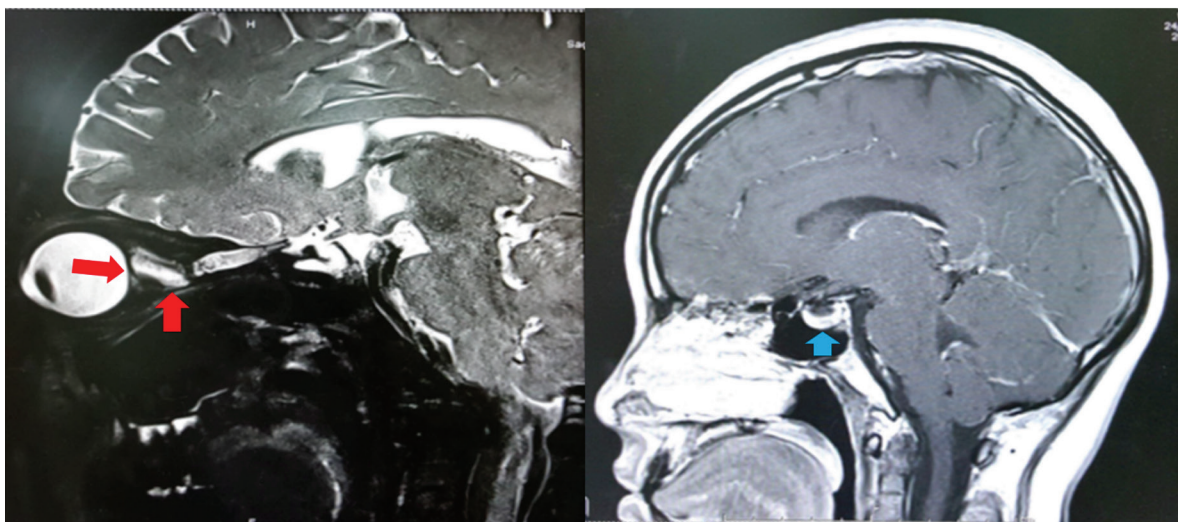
Sagittal view of contrast-enhanced brain MRI showed partial empty sellar (blue arrowhead), dilated CSF spaces around bilateral optic nerves with tortuosity and mild flattening of the posterior sclera (red arrowhead).
